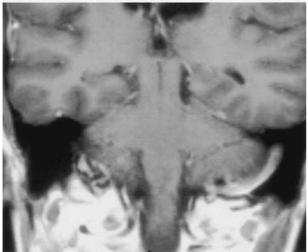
Case no. 1. Preoperative (*upper*) and postoperative (*lower*) coronal MR images of craniocervical meningioma
